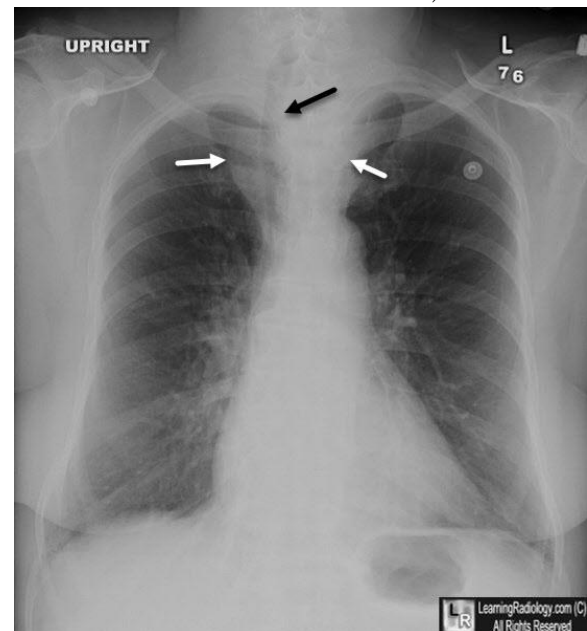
chest X-ray showing a retrosternal goiter with marked deviation of the trachea to the right (arrow).
